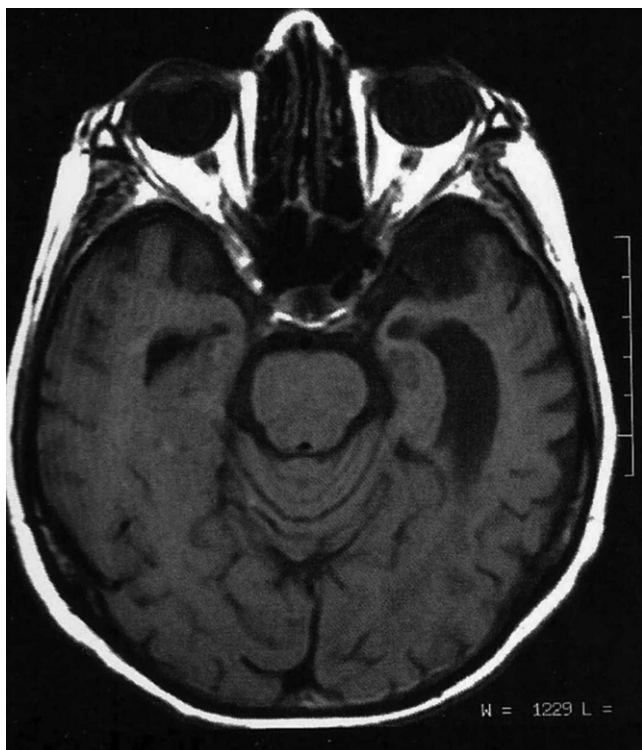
MRI (axial T1) showing focal atrophy of the left temporal lobe.
